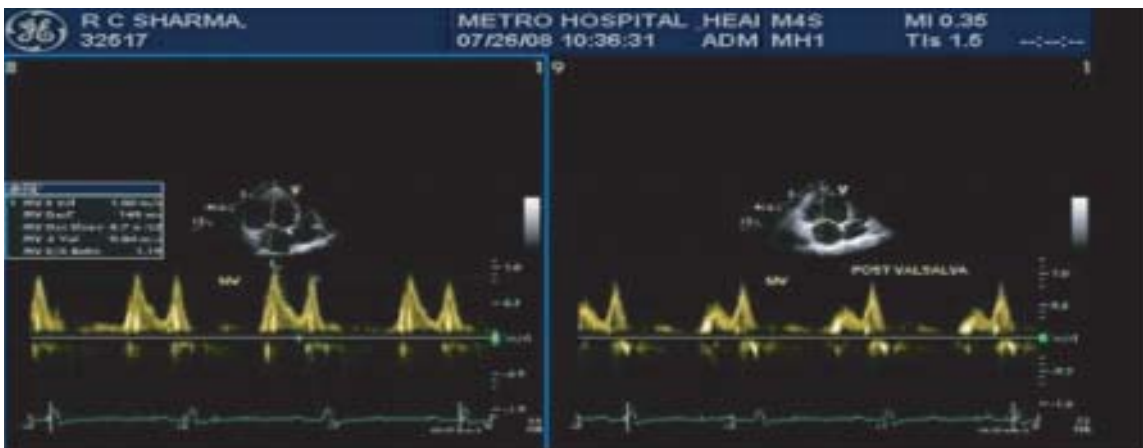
Mitral Doppler with a pseudonormal pattern (Grade II diastolic dysfunction) changing to impaired relaxation following valsalva (right panel).
